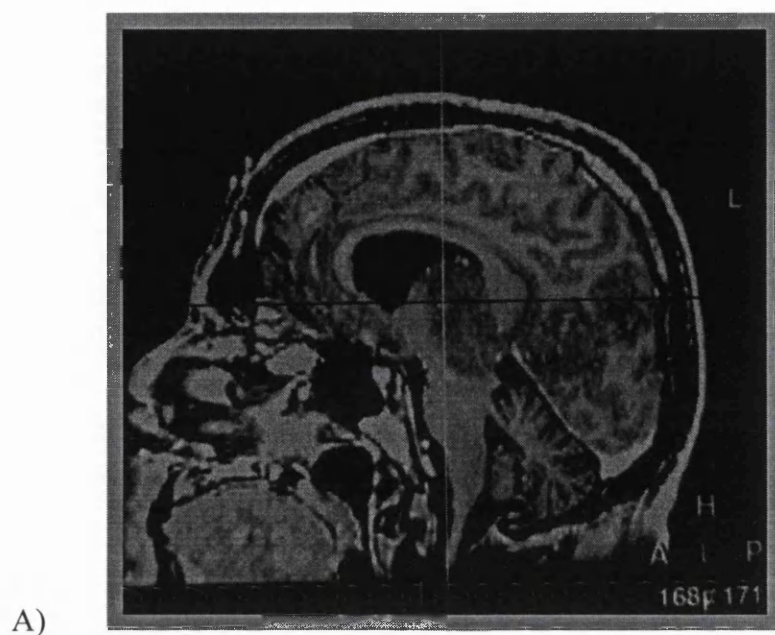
MR images acquired during the frameless stereotactic biopsy study. These sagittal images, of case 5 in the clinical series, demonstrate a) the captured intra-operative target and b) the post-operative appearance of the biopsy site.
